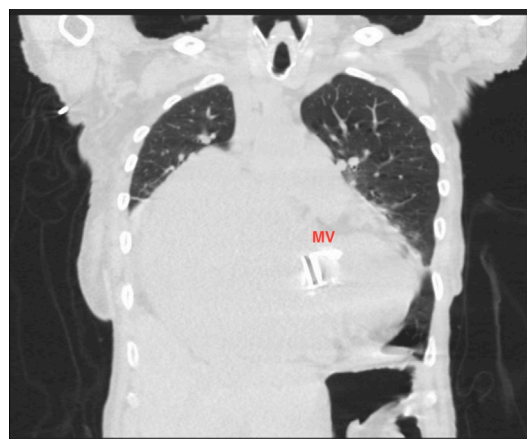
A coronal view of a CT chest demonstrating massive cardiomegaly with collapse of the right lower and right middle lobe.
